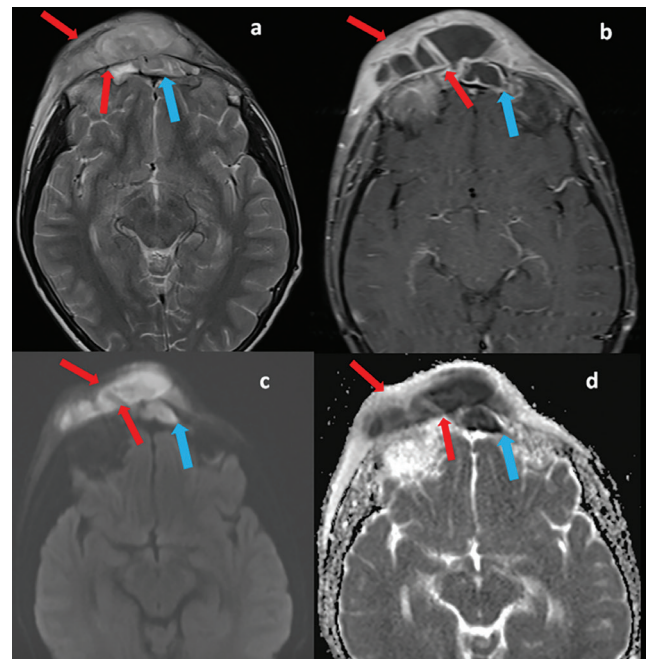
Twelve-year-old male with frontal sinusitis complicated by subperiosteal abscess formation. Contrast-enhanced brain MRI (a, b) and diffusion-weighted imaging (c, d) demonstrate frontal sinusitis with erosion of the anterior sinus wall and a rim-enhancing, loculated subperiosteal collection along the frontal bone (red arrow), showing diffusion restriction consistent with an abscess. The affected frontal sinus exhibits mucosal thickening and fluid accumulation (blue arrow), indicating active inflammation. Adjacent subgaleal soft tissue edema and enhancement are also evident, supporting the diagnosis of Pott's puffy tumor secondary to frontal sinusitis
